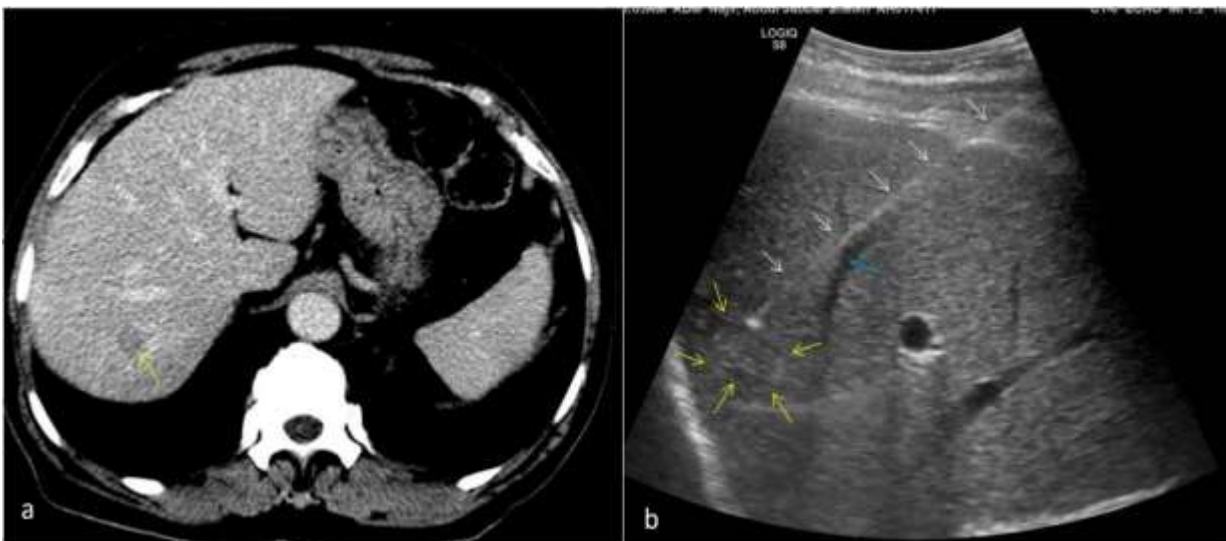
In this treated case of carcinoma rectum, surveillance CT scan reveals a 13 mm nodule in segment VII of liver (yellow arrow in a). USG guided FNAC was performed from this small liver lesion (as shown in b, yellow arrows). Entire course of the 15 cms 23G chiba needle (white arrows) is seen when the needle is parallel to the transducer. Tip of the needle is seen in mildly hyperechoic liver lesion in segment VIII (yellow arrows). Blue arrow shows hepatic vein. Cytology report suggestive of metastasis.
